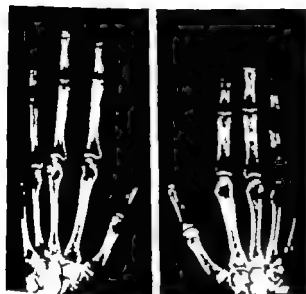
Case 4 Conventional radiograph of the hands
